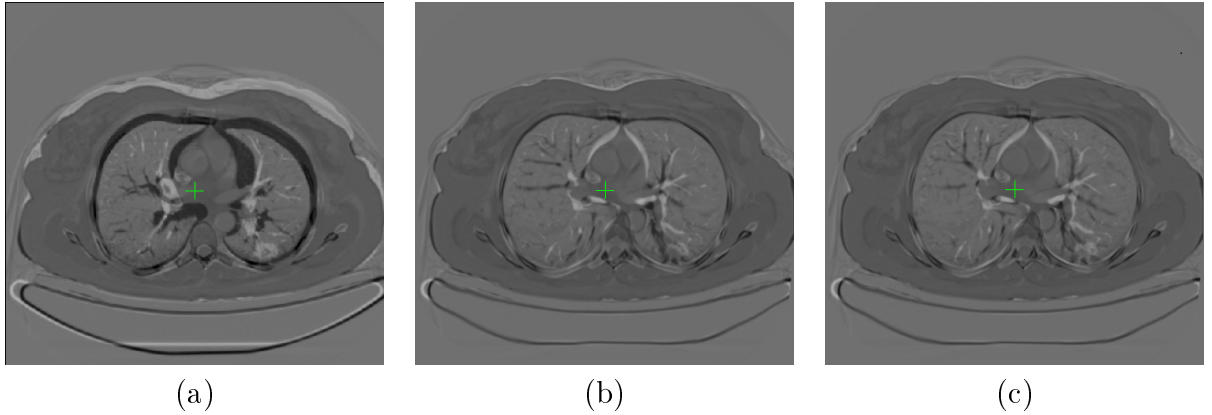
Difference image between diagnostic CT and AC-CT images (Patient 6). (a) without registration (b) with classic fluid registration (c) with our proposed registration technique.
